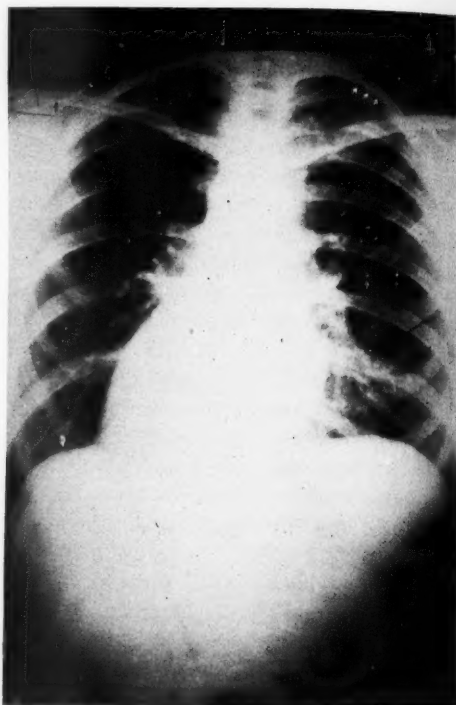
Radiograph showing same conditions as in Figure 2. The lesion here represented is probably one of the earliest indications of tuberculous disease.
